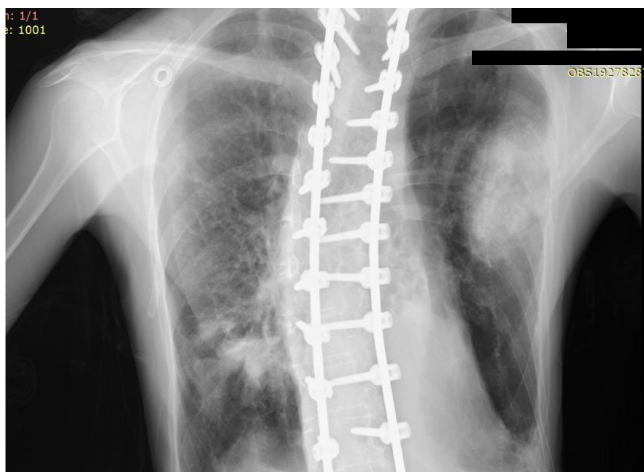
PA chest x-ray revealed nearly homogeneous increase of density in the lateral part of left lower lung zone and infiltration in the infrahilar region of right lower lung zone. The platinization used in scoliosis operation was patent
